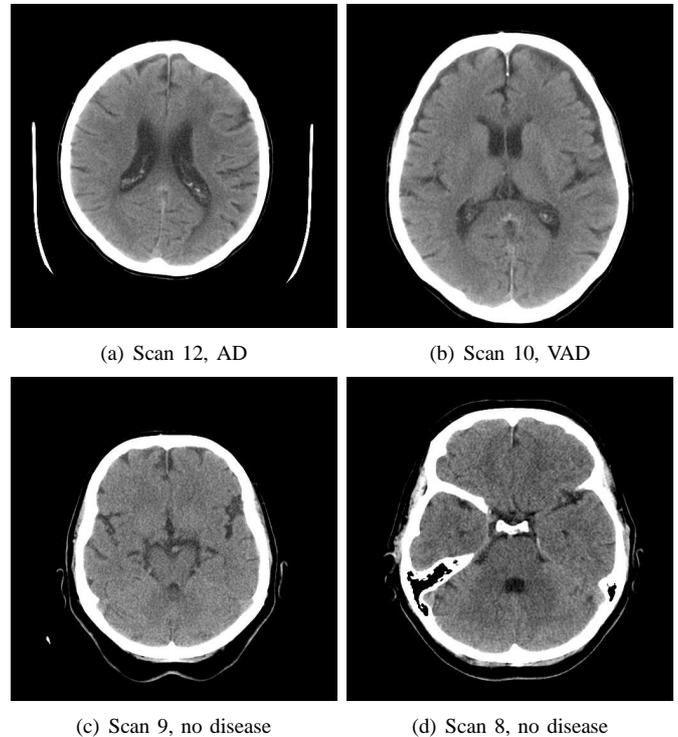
Exemplary CT scans for various patients. Patient (a) has *Alzheimer disease*, (b) has *Vascular Dementia*. patients (c) and (d) have no disease.
